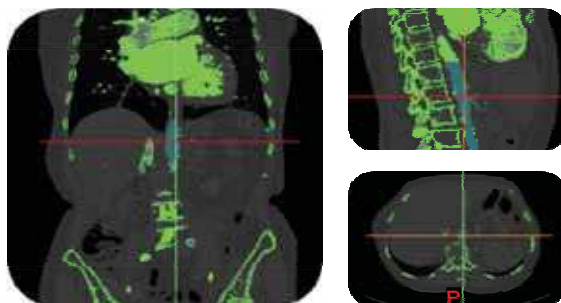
Two-dimensional CT images and the result of the image segmentation.
